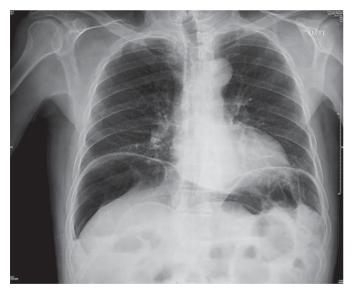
Chest radiograph revealing free air under both hemidiaphragms (pneumoperitoneum).
